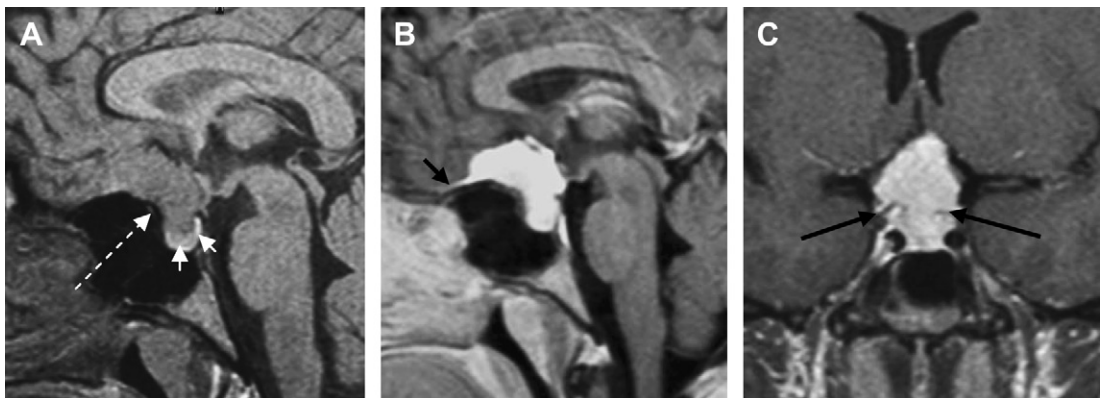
Sagittal T1-weighted image (A) and gadolinium-enhanced sagittal (B) and coronal (C) T1-weighted images show a dural-based lesion along the posterior aspect of the planum, transgressing the diaphragm and growing into the sella, compressing the pituitary gland against the sellar floor (*small white arrows in A*). Note the hour-glass shape of the lesion, which is best appreciated on the coronal plane, with a stricture at the sellar diaphragm (*black arrows in C*). The lesion is isointense with gray matter and enhances homogeneously, showing a thin dural tail along the planum (*small black arrow in B*). Bone sclerosis, with blistering of the sphenoid roof (*dashed white arrow in A*) and pneumosinus dilatans, can also be seen (sphenosellar meningioma).
